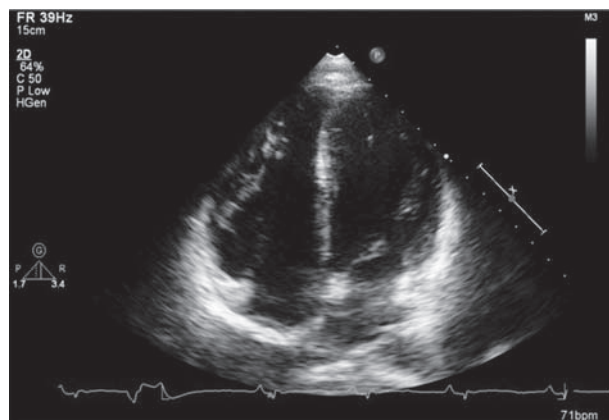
Two-dimensional echo apical four chamber showing right ventricular free wall infiltration.
